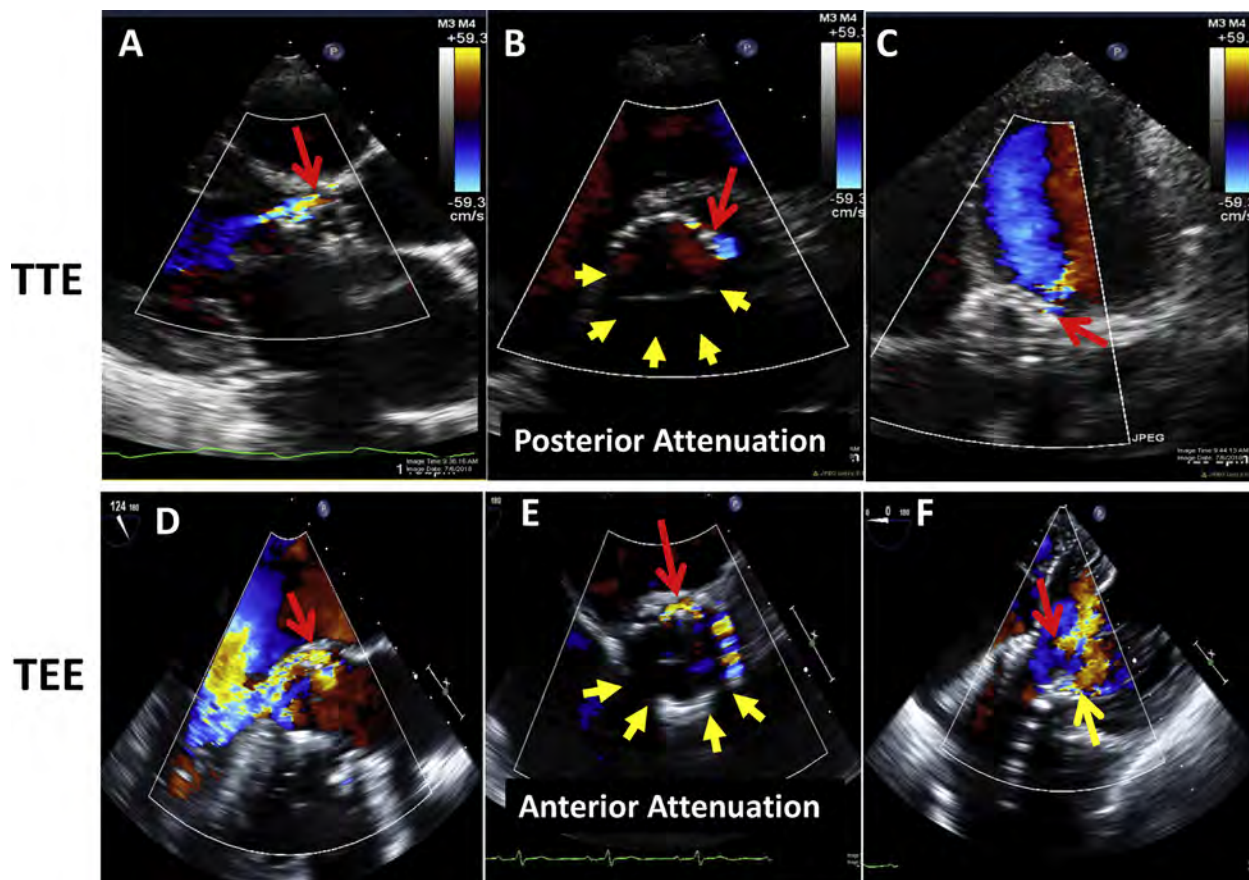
Demonstration of paravalvular leaks after TAVR assessed by TTE and TEE in two different patients, demonstrating ultrasound attenuation of the valve ring and adjacent structures by the prosthetic valve, and the importance of comprehensive color Doppler imaging from the apical views (apical in TTE and transgastric in TEE). Panels A to C demonstrate an anterior paravalvular leak that is identified from a parasternal long-axis view (A), short-axis view (B), and modified apical five-chamber view (C). There is posterior attenuation (yellow arrows). Panels D-F demonstrate posterior paravalvular leak on mid-esophageal 120 degrees (D) and short-axis views (E); the transgastric view (F) demonstrates two jets of paravalvular regurgitation, one jet is anterior and the other is posterior. Without careful comprehensive interrogation, the anterior leak would have been potentially missed on just mid-esophageal views because of attenuation (yellow arrows).
